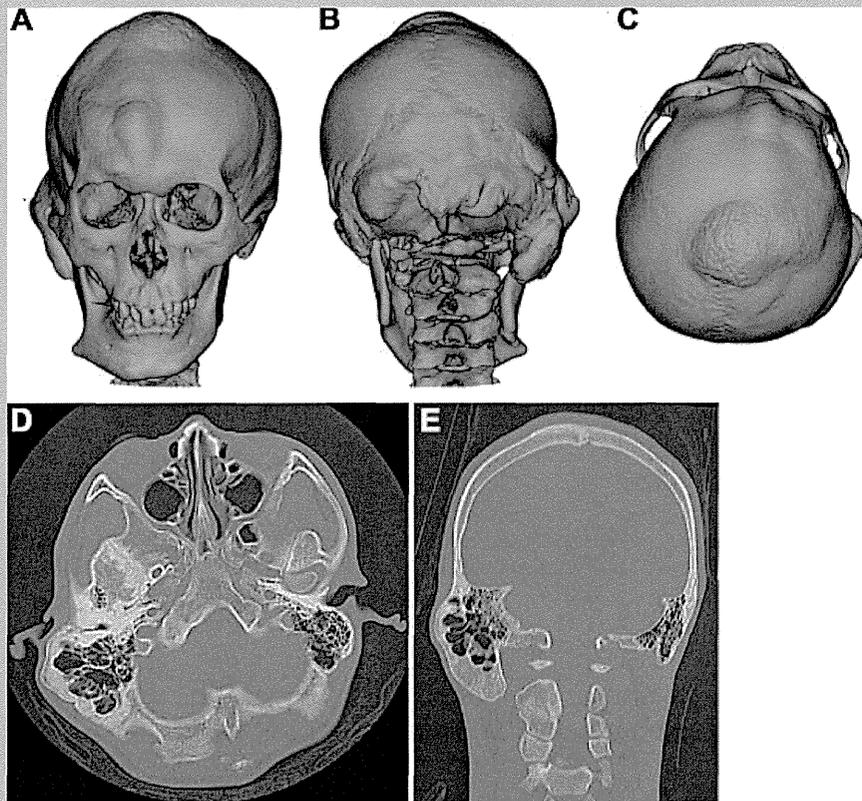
Preoperative volume-rendered computed tomography (CT) shows hyperostoses of the right paramedian area of the frontal bone, from the mid- to right-side of the frontoparietal bones along the coronal suture, the bilateral nuchal line and the posterior tubercle of the occipital bone, the right lambdoid suture and occipitotemporal suture area, the right side of the mandible, the right side of the cervical spine [A–C]. Axial computed CT without contrast showing enlarged mastoid cells with preserved pneumatization on the right, and stenosis of the right external auditory canal caused by hyperostoses [D]. The coronal view shows hyperostoses of the right side of the cervical vertebrae from C2 to C5 and fusion of the right side of the cervical vertebrae between C2 and C3 are evident [E].
